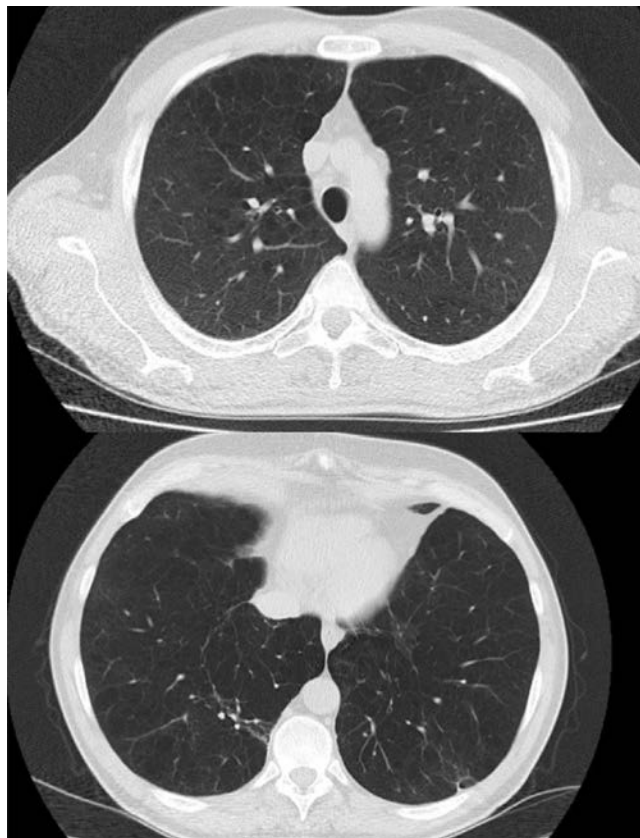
Chest computed tomography demonstrating diffuse emphysematous changes in both lungs.
